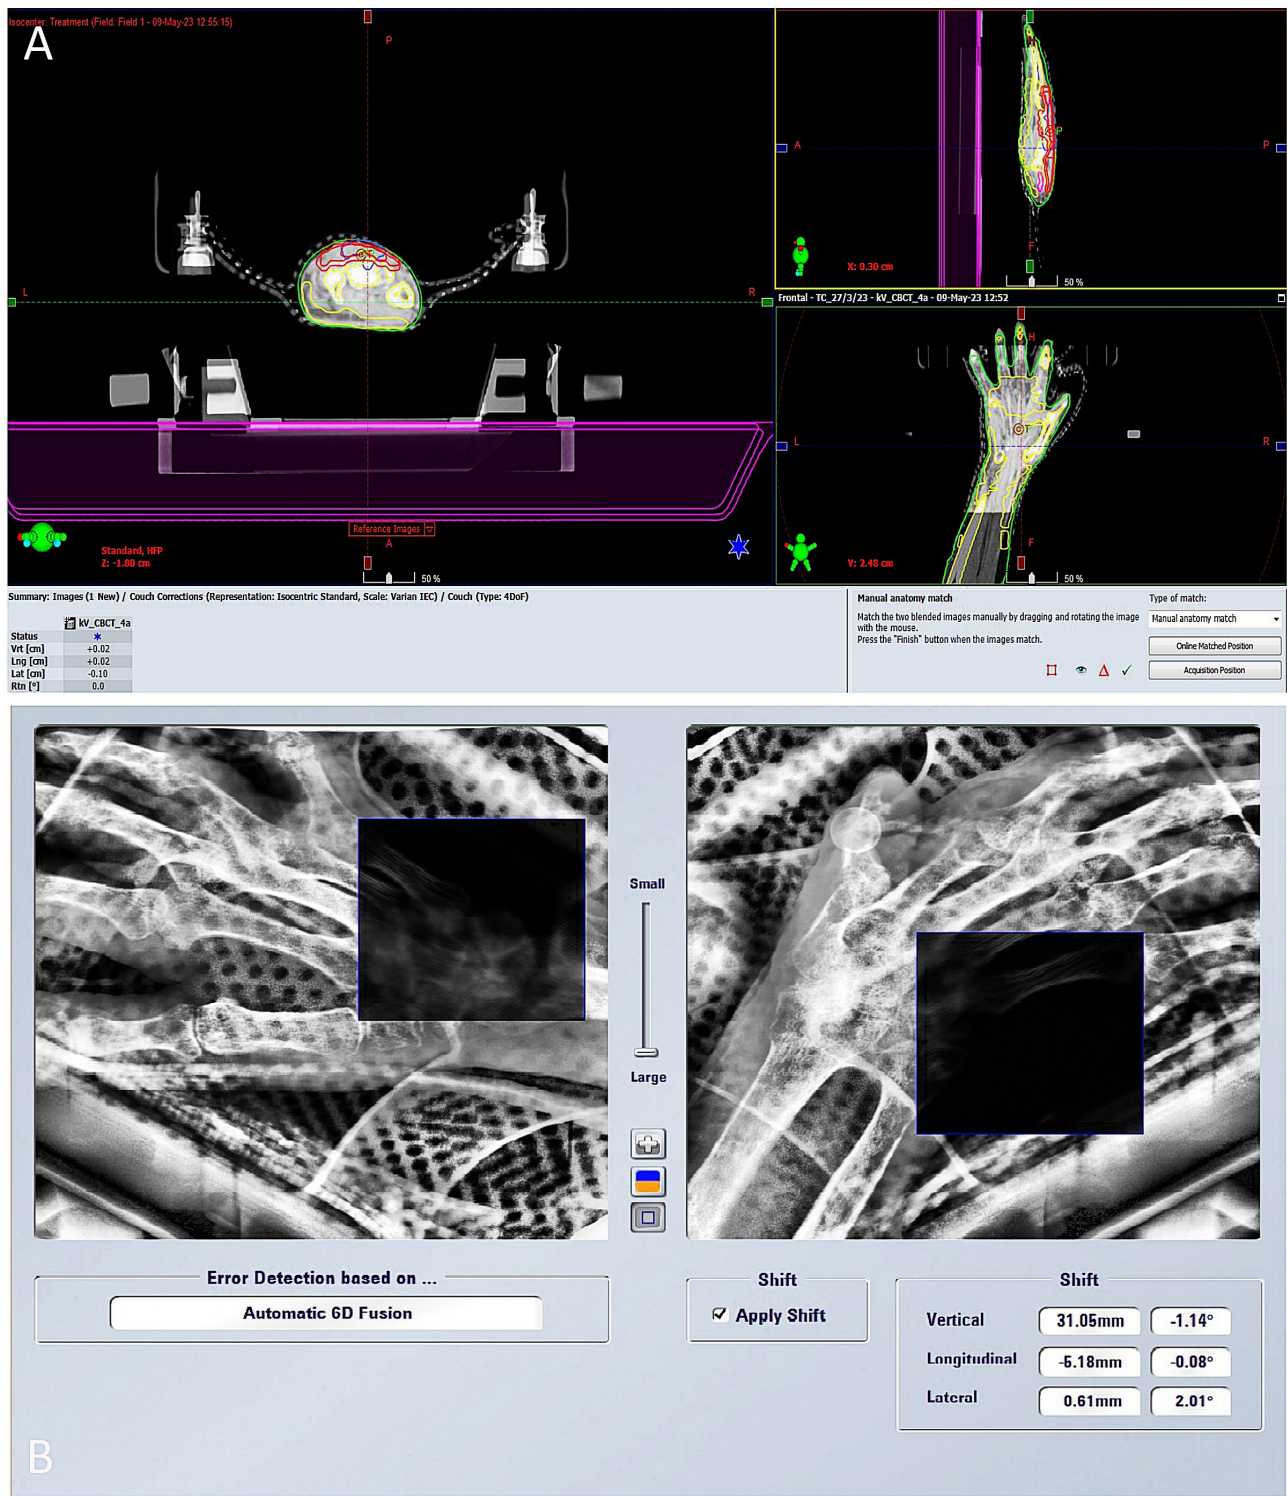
Verification of treatment setup using cone-beam CT and ExacTrac imaging systems. (A) Treatment setup verification using cone-beam CT. (B) Treatment setup verification using ExacTrac.
